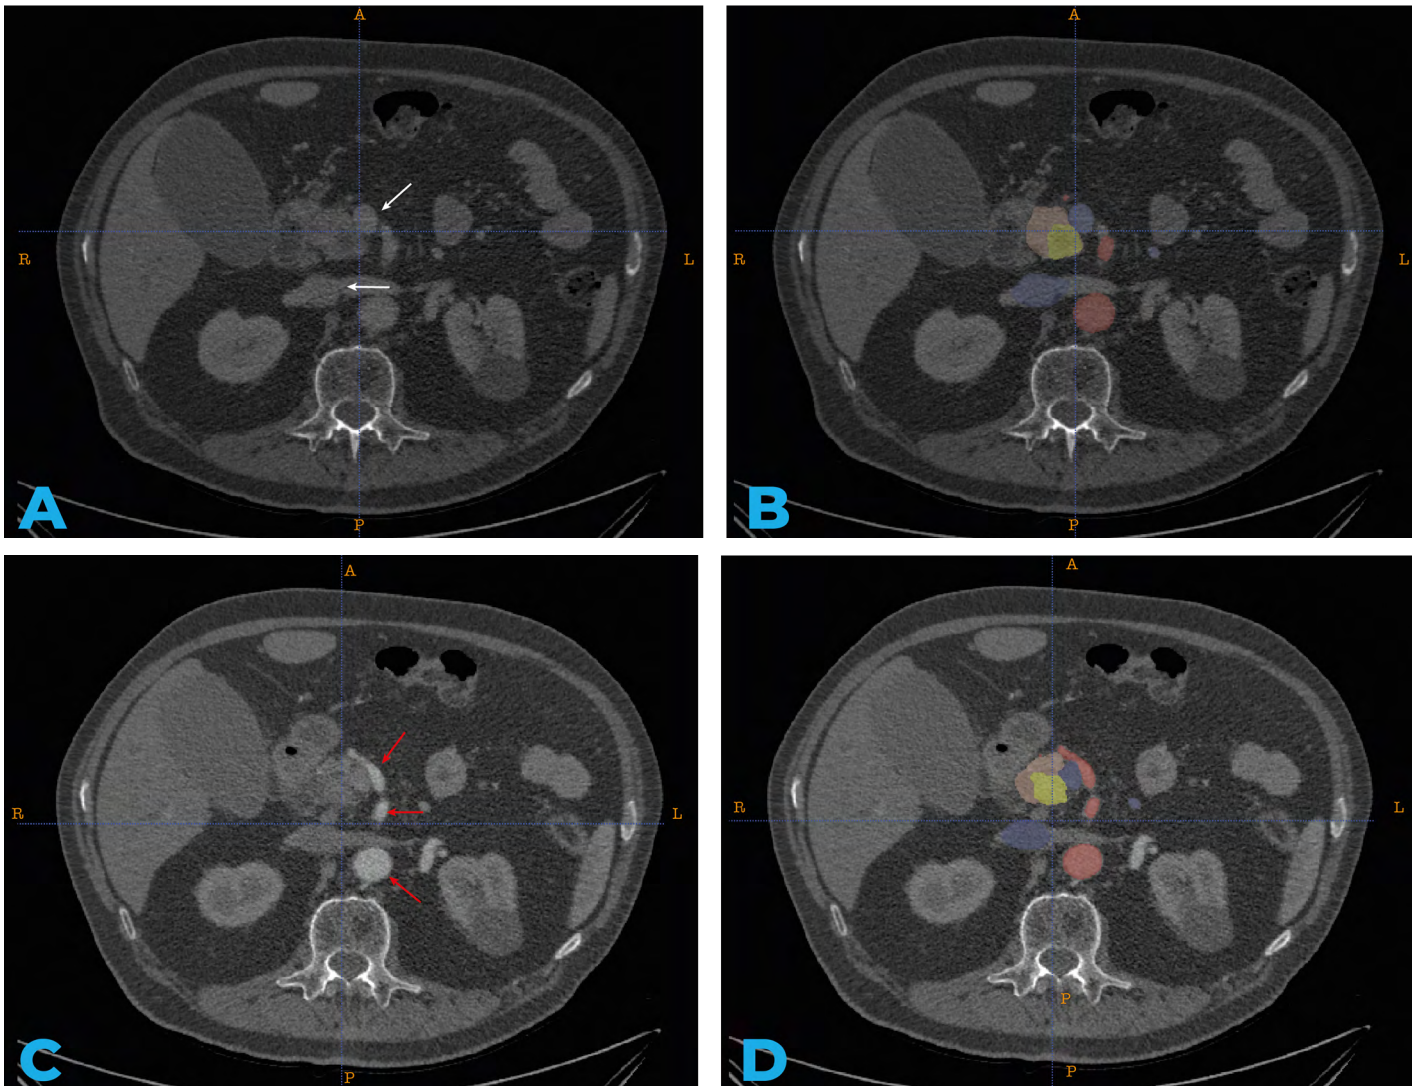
CT scan with contrast-enhancement from a patient with pancreas cancer treated in Catharina Hospital Eindhoven. (A) Portal-venous phase scan without annotations, white arrow indicating the veins. (B) Portal-venous phase scan with annotations yellow = tumour, red = arteries, blue = veins, light brown = pancreas. (C) Arterial phase scan without annotations, red arrow indicating the arteries. (D) Arterial phase scan with annotations, yellow = tumour, red = arteries, blue = veins, light brown = pancreas.
